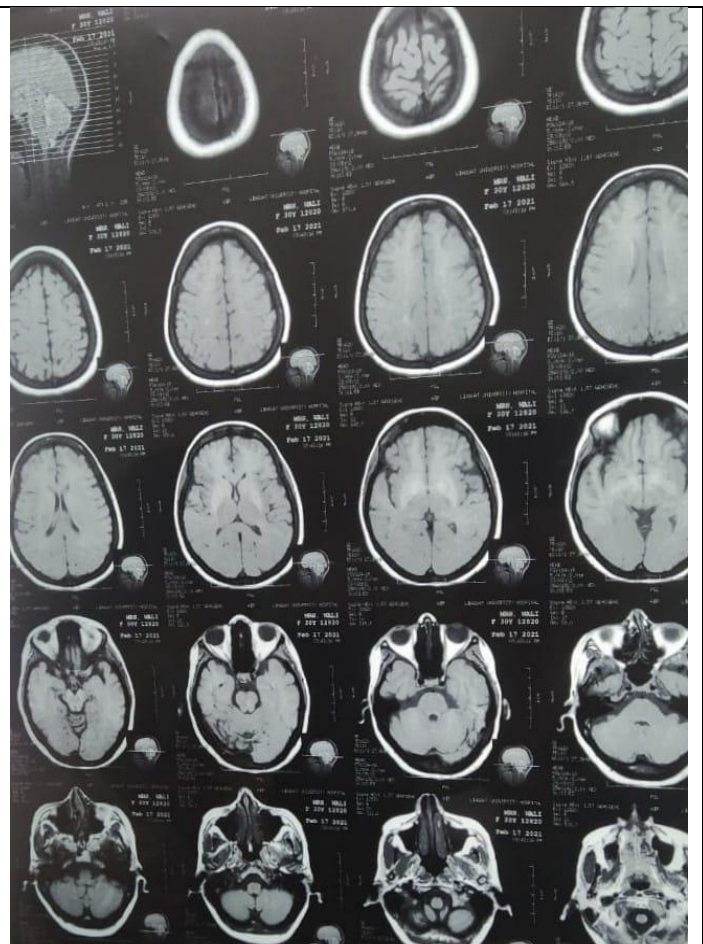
MRI Scan of the patient diagnosed with PRES Syndrome
